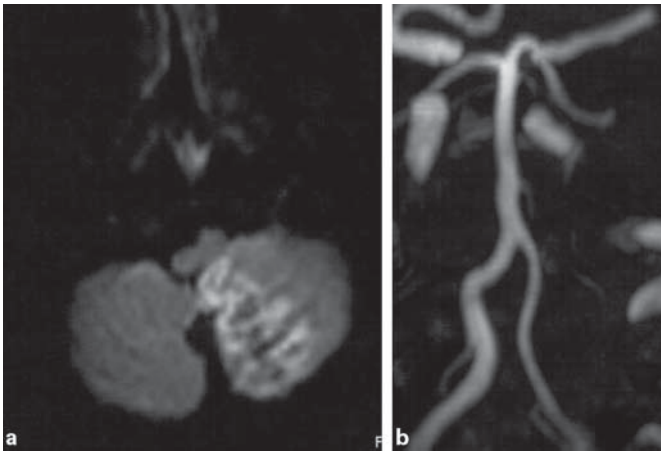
a Diffusion-weighted MRI demonstrating an ischemic infarction in the territory of the left posterior inferior cerebellar artery. b MR angiography showed normal posterior circulation vessels except for a slight hypoplasia of the left vertebral artery.
